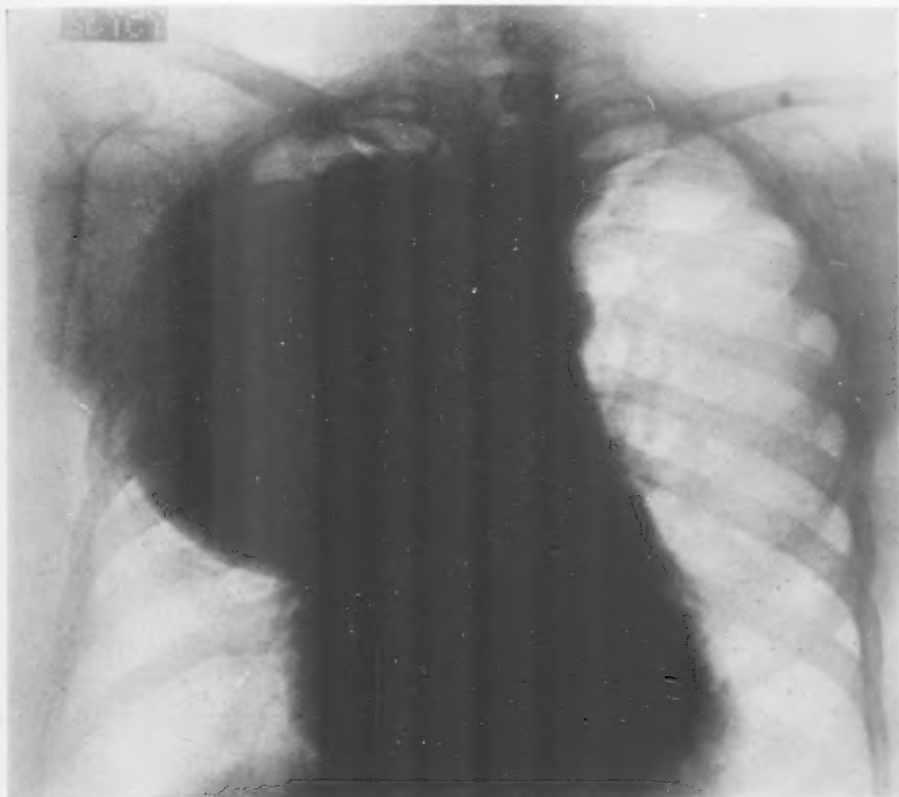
X-ray of Case V, showing a circumscribed shadow in upper half of the right thoracic cavity.
